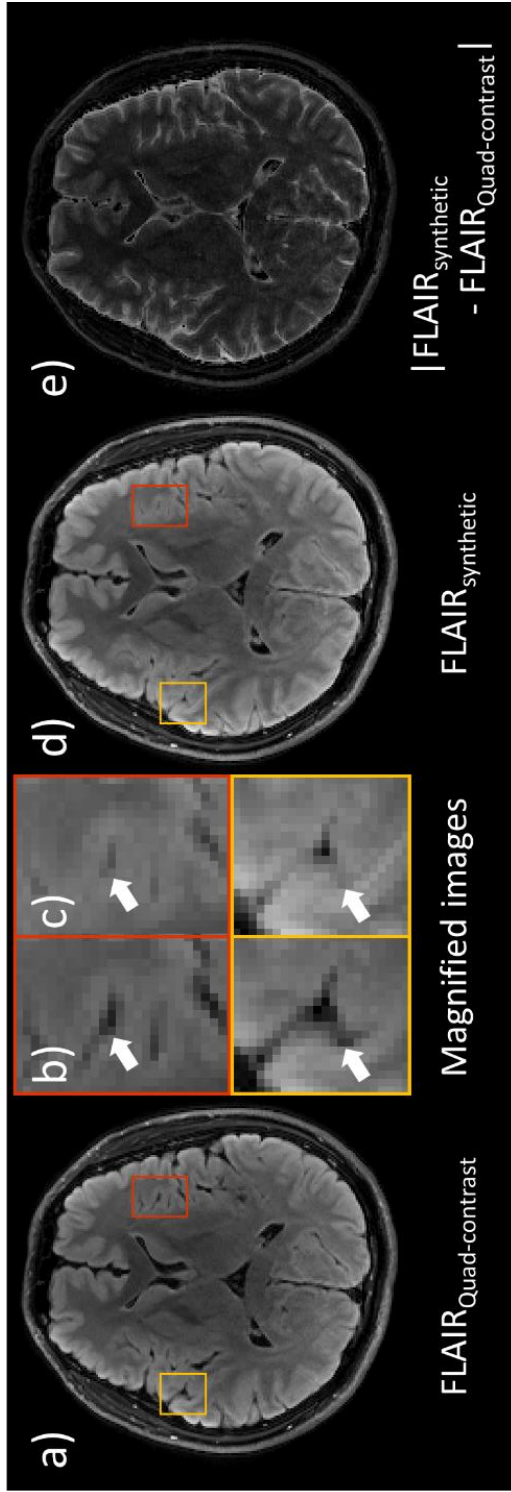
a) $\text{QuadCont}_{\text{DL-pro}}$ FLAIR image ($\text{FLAIR}_{\text{Quad-contrast}}$), b) magnified image of a), c) magnified image of d), d) synthetic FLAIR image ($\text{FLAIR}_{\text{synthetic}}$), and e) the absolute difference between the synthetic FLAIR and $\text{QuadCont}_{\text{DL-pro}}$ FLAIR images. The synthetic FLAIR image, in contrast to the native FLAIR image, displays hyperintense interface of CSF and brain parenchyma (arrows in b, c). When the absolute difference between the two FLAIR images are observed, the CSF boundaries are highlighted, clearly showing the hyperintense CSF boundary artifacts present in the synthetic FLAIR image.
